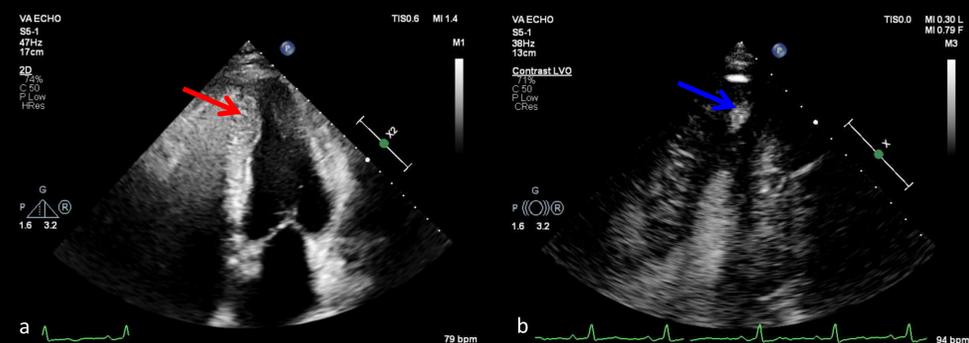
Transthoracic echocardiogram 4-chamber view showing marked apical left ventricular hypertrophy (red arrow) in diastole (a). During systole (b), there is apical dyskinesia with the formation of a small (<3cm) apical aneurysm (blue arrow) that can be visualized after contrast administration.
